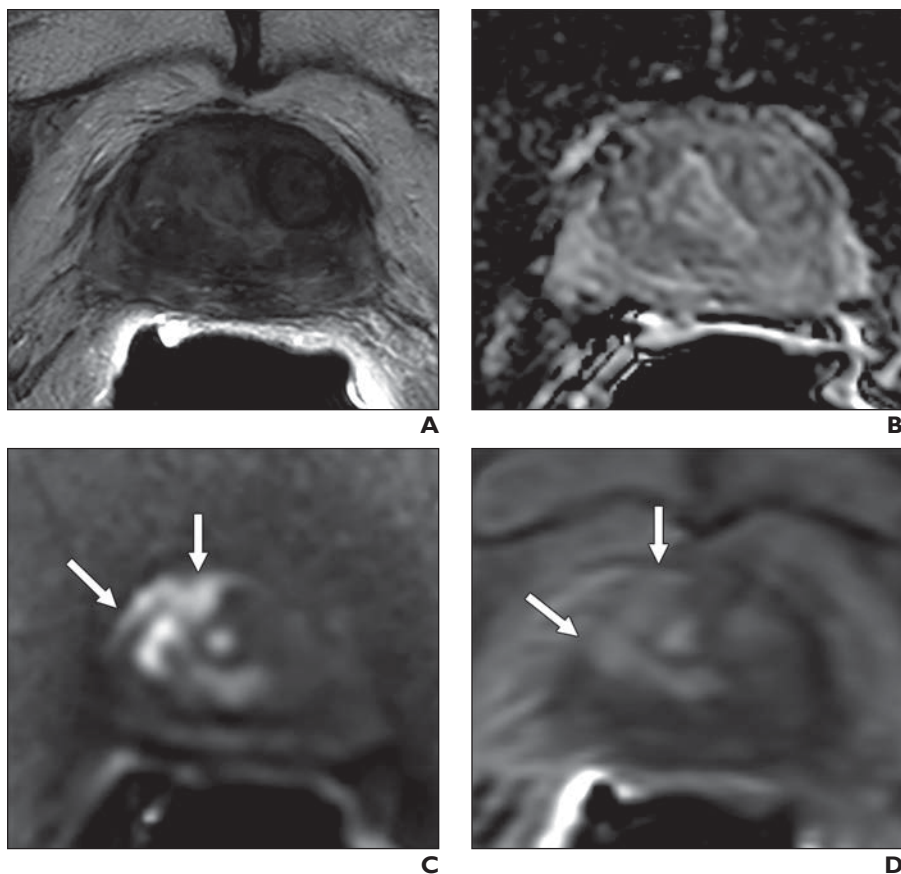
82-year-old man with history of external beam radiation therapy for localized prostate cancer who presented with serum prostate-specific antigen value of 9.33 ng/mL. Patient was referred for multiparametric MRI. A, T2-weighted image shows diffusely heterogeneous signal pattern without evidence of focal lesion. B, Apparent diffusion coefficient map shows unremarkable findings. C and D, High-b-value DW image (C) and dynamic contrast-enhanced MR image (D) show focal lesion in right mid anterior transition zone (*arrows*). Targeted biopsy revealed recurrent prostate cancer within this lesion.
